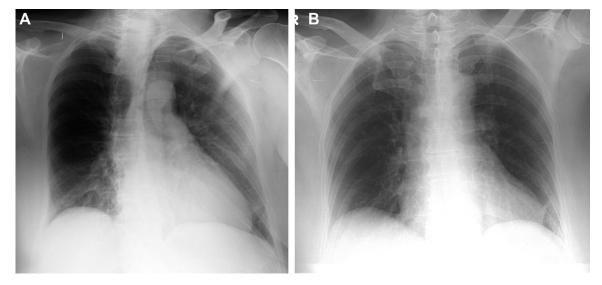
A, Portable anterior-posterior chest radiograph in a 75-y-old man with right anterior oblique positioning. The right hemithorax appears more hyperlucent because of increased x-ray transmission from closer proximity to the x-ray beam. B, Repeat nonrotated chest radiograph in the same patient showing symmetrical appearances.
